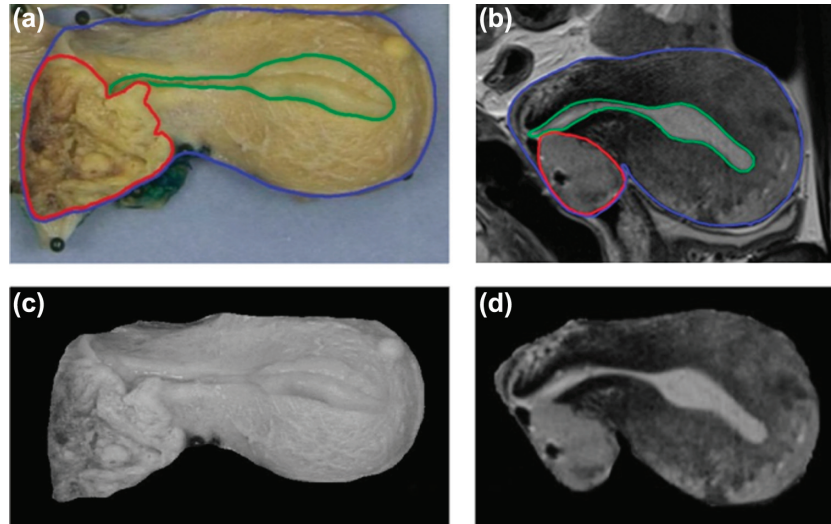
An example of a 2D digital photo of the macroscopic intersection (a) and the corresponding 2D sagittal MR image (b) with delineated structures [cervix-uterus (blue), uterine cavity (green), GTV (red)]. The cervix-uterus structures were segmented from the background on the photo (c) and from surrounding tissue on MRI (d).
